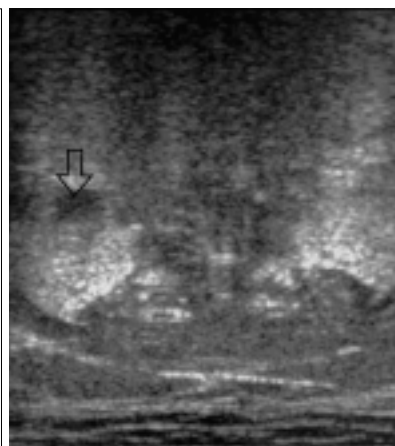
Parathyroid adenoma with hyperparathyroidism. Transverse ultrasonographic scan shows a solid oval mass posterior to the thyroid.
